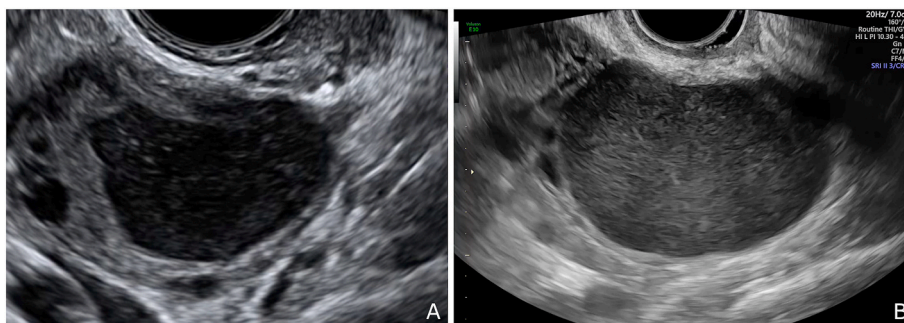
Endometriomas appear at ultrasound in a premenopausal patient as an adnexal mass with ground glass echogenicity of the cyst fluid, one to four locules and no papillations with detectable blood flow (a and b). In the case of large endometriomas, the ovarian follicles appear laterally compressed by the cyst.
